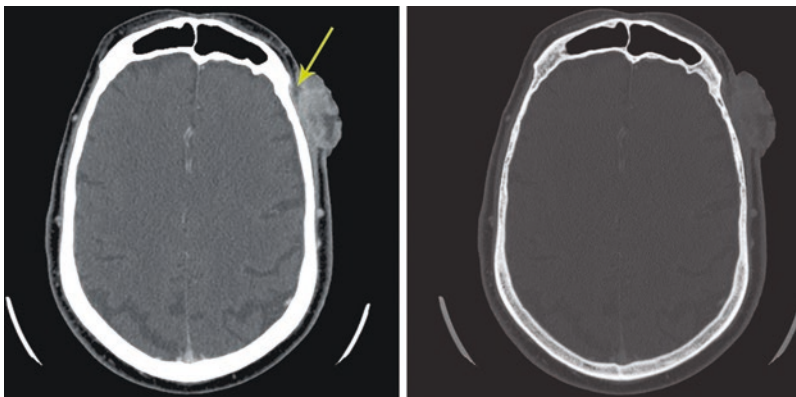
Left:* Axial post-contrast CT image through the frontal sinus demonstrates invasion of the temporalis musculature. *Right:* Bone window of the same CT image demonstrates no cortical erosion. No adenopathy was
